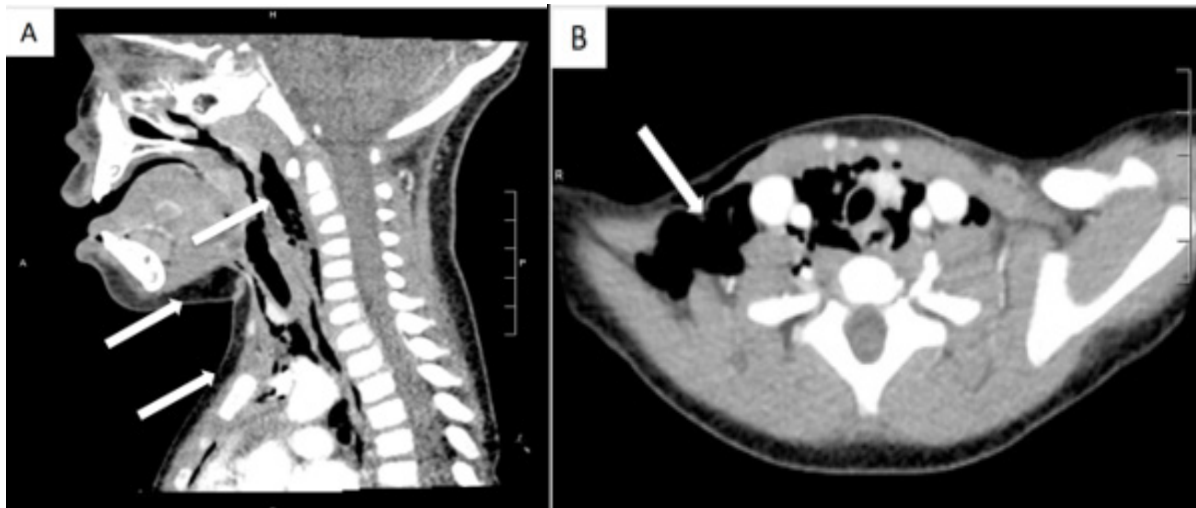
Computed tomography of the neck (A) and chest (B) confirmed subcutaneous air (arrows) tracking inferiorly into the mediastinum, without abscesses or necrotic nodes.
